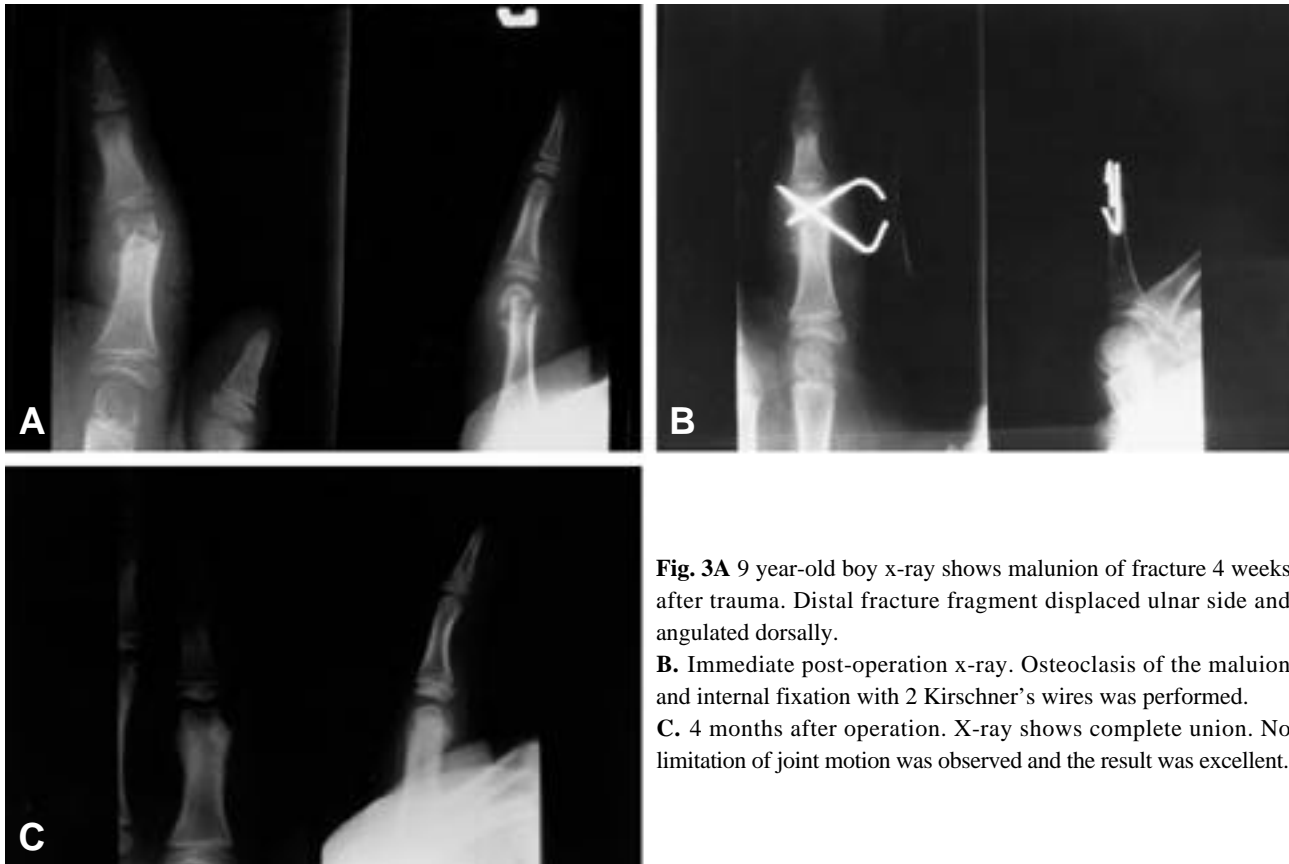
9 year-old boy x-ray shows malunion of fracture 4 weeks after trauma. Distal fracture fragment displaced ulnar side and angulated dorsally.
